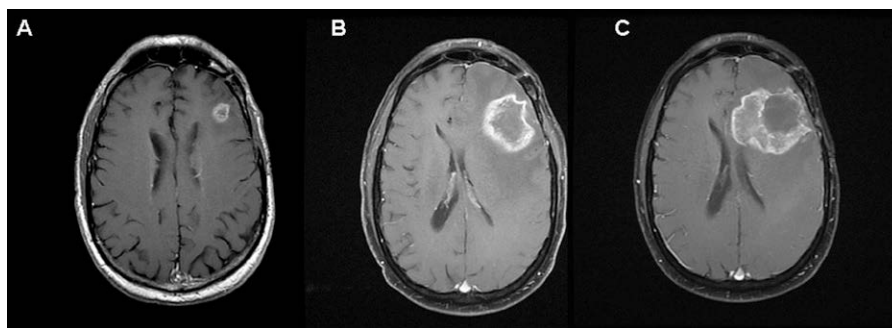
T1 postcontrast axial magnetic resonance imaging (MRI) images of the brain. (A) Stable enhancing pattern ~6 months after stereotactic radiosurgery. (B) Progressive enhancement is noted ~7 months after stereotactic radiosurgery. (C) Two months after resection revealing radiation necrosis, there is additional progression of enhancement.
